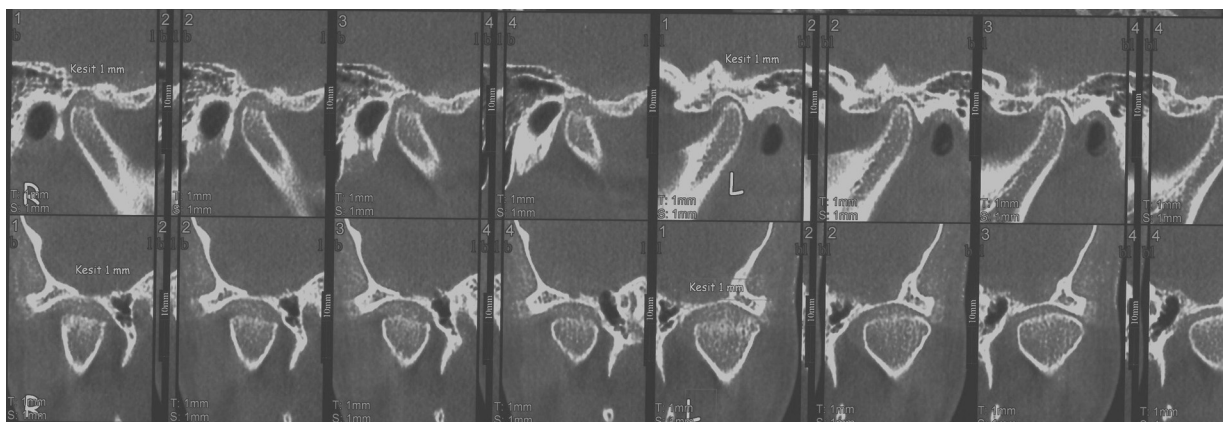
CBCT images of a case with bilateral TMJ osteoarthritis (coronal and sagittal views).
